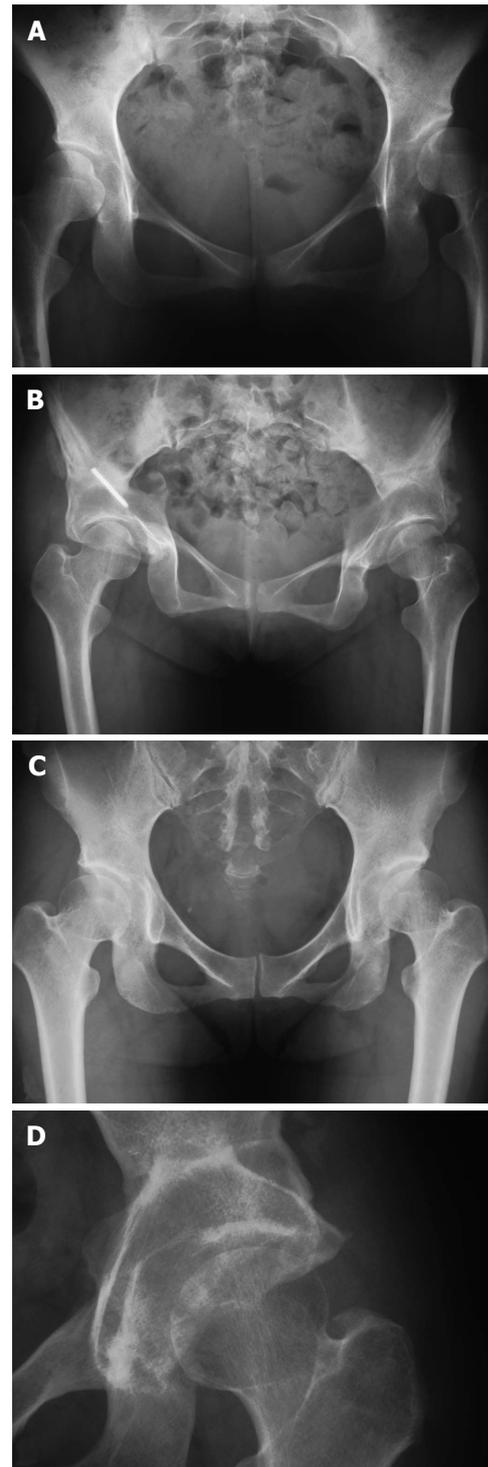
Anteroposterior X-ray images of cases 1, 2 and 5. A: Pre-operative anteroposterior (AP) X-ray images of cases 1 and 2 showing pre-osteoarthritis in a patient with bilateral developmental dysplasia of the hip (DDH); B: Post-operative AP X-ray image at the final follow-up examination. Three 3.0 mm K-wires were used for fixation of the acetabulum. One of the K-wire was remained at the right hip; C: Pre-operative AP X-ray image showing pre-osteoarthritis in a patient with bilateral DDH; D: Post-operative AP X-ray image at the final follow-up examination.
